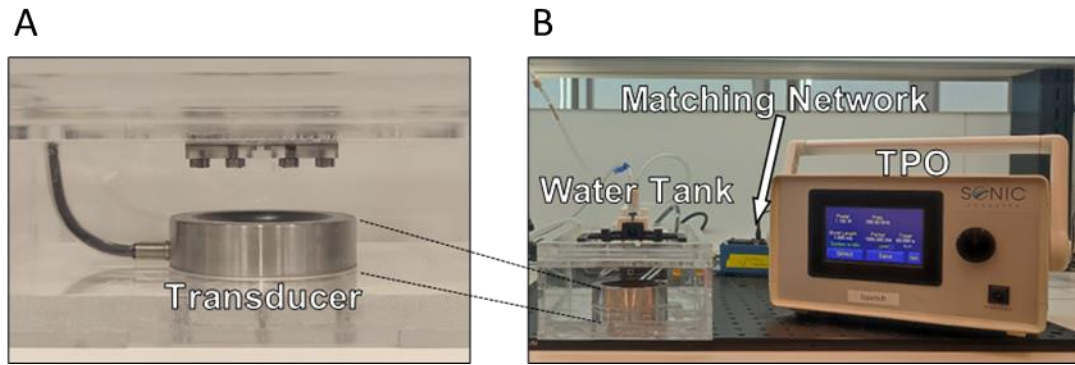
Therapeutic ultrasound setup. A) H115 single element therapeutic transducer positioned at the bottom of a degassed and deionized water tank. B) The complete ultrasound setup comprising the transducer power output unit that combines an arbitrary waveform generator with a radiofrequency amplifier, the matching network and the water tank with the therapeutic single element transducer.
